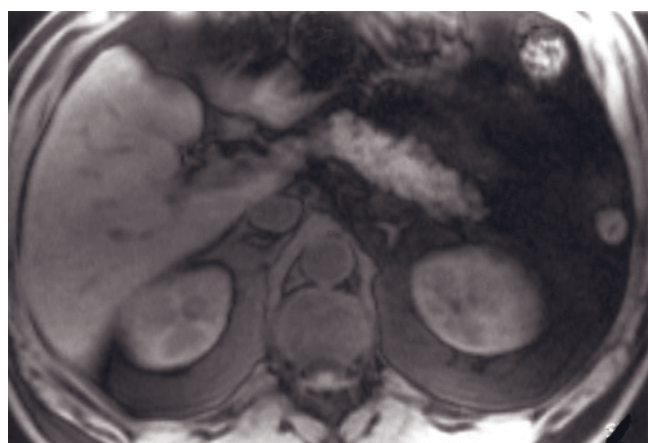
Normal adrenals. Coronal T2-weighted HASTE (a), T1-weighted GE (b), T1-weighted fat-suppressed GE (c), T1-weighted out-of-phase GE (d), HASTE (e), immediate postgadolinium T1 GE (f), and 90-s postgadolinium T1 fat-suppressed GE (g) images.
